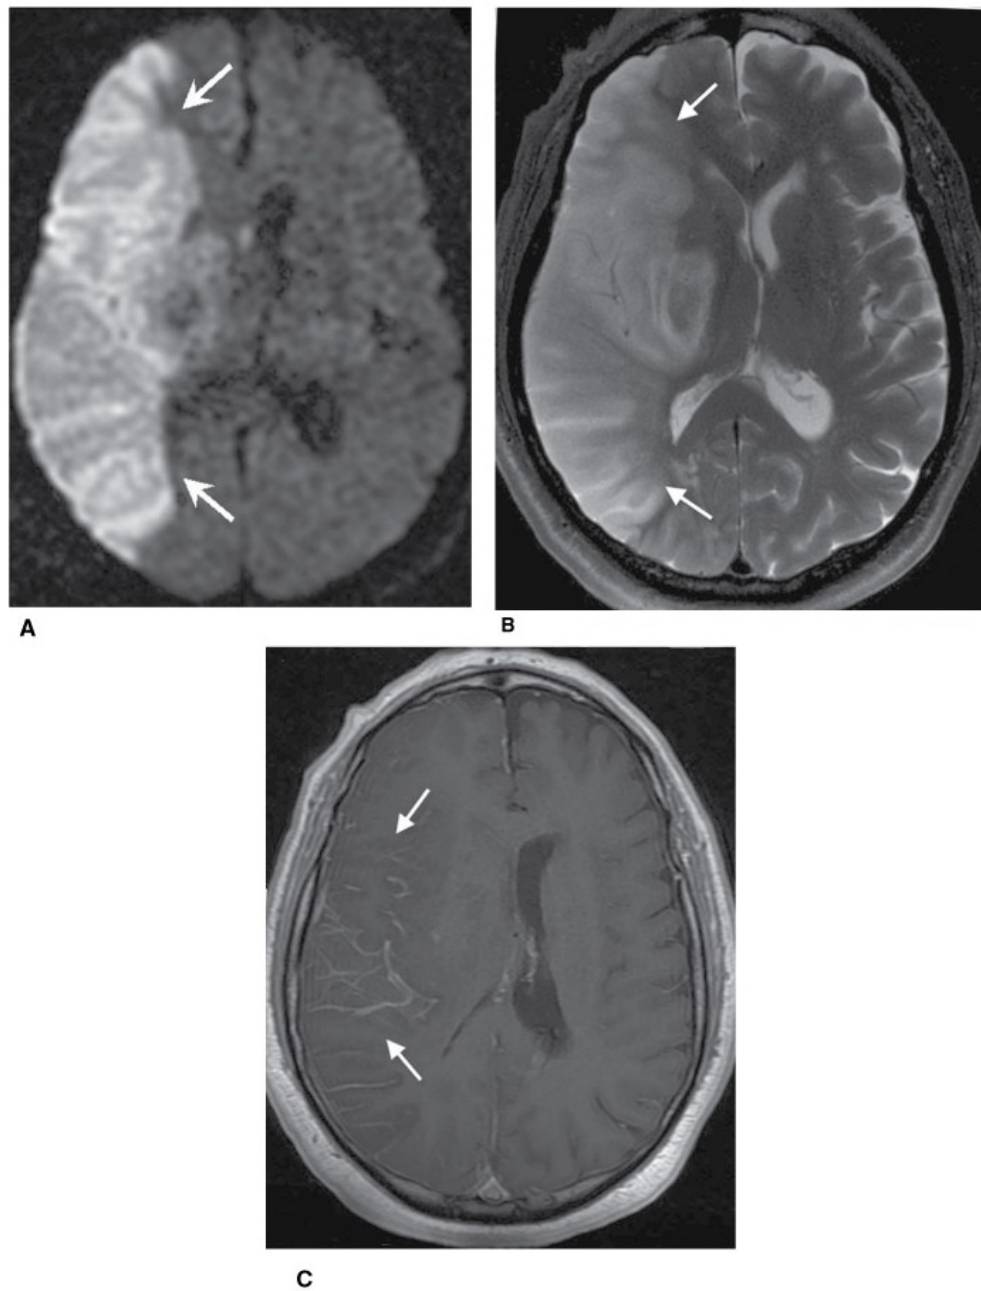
Axial MR images of the patient with right MCA territory infarction shown in Figure 1.10. Images are at the same anatomic level. A. DWI demonstrating restricted movement of water in the infarcted area (increased signal intensity between white arrows). B. T2-weighted image demonstrating area of hyperintensity and mass effect on surrounding structures. C. T1-weighted image with contrast injection showing enhancement of vasculature in the territory of infarction, corresponding to slow flow of intravascular contrast. Images adapted from: Chen, Pope and Ott. *Basic Radiology*, 2nd edition, Chapter 12.
